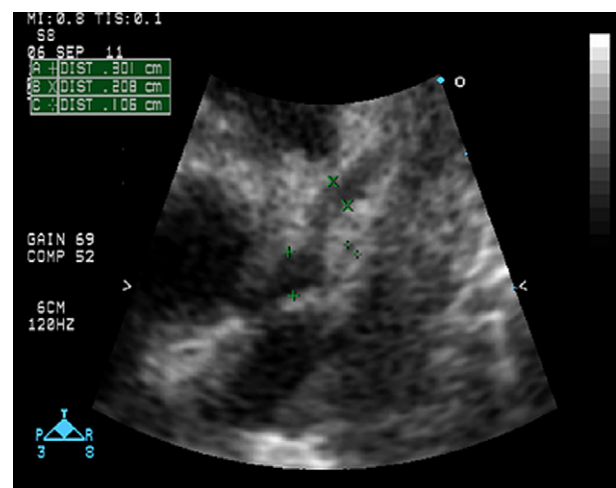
A 3-month-old male infant with acute-stage Kawasaki disease. Precordial echocardiography showing a dilated LMCA (diameter: 0.301 cm) and LAD (diameter: 0.208 cm). The estimated coronary diameter in healthy infants when adjusted for body surface area is 0.170 ± 0.057 cm (mean \pm SD) for LMCA and 0.132 ± 0.048 cm for LAD [40]. LAD: left anterior descending coronary artery, LMCA: left main coronary artery, SD: standard deviation.
